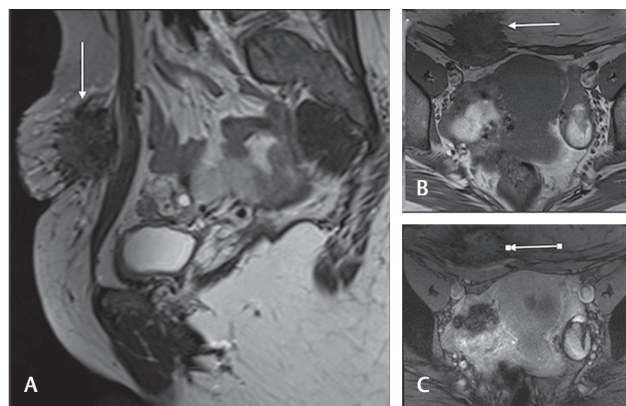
(A–C) T2W sag (A), T1W (B), and gradient (C) axial images showing a spiculated mass in the anterior abdominal wall, involving the rectus abdominis muscle. It shows low SI on T1W and T2W images (*arrows* in A and B) and blooming on the gradient images (*arrow* in C), suggestive of blood products. SI, signal intensity; T1W, T1-weighted; T2W, T2-weighted.
